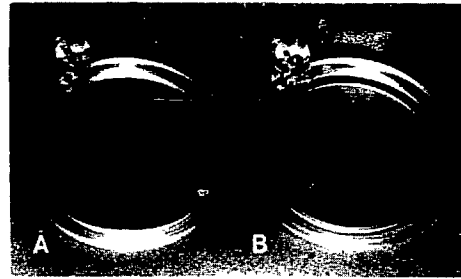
The plastic rings into which the roentgen tube fits. A. locator ring through which the tube passes. B. ring with a flange which arrests the tube.
